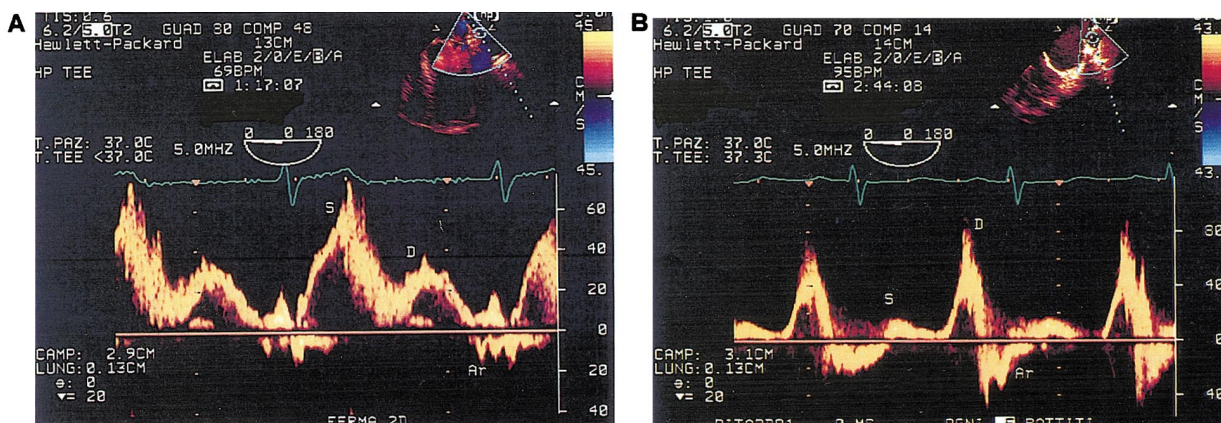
Transesophageal pulmonary venous Doppler flow profiles in a normal subject (A) and a patient with altered diastolic function (B) showing increased diastolic flow “D” velocity.
